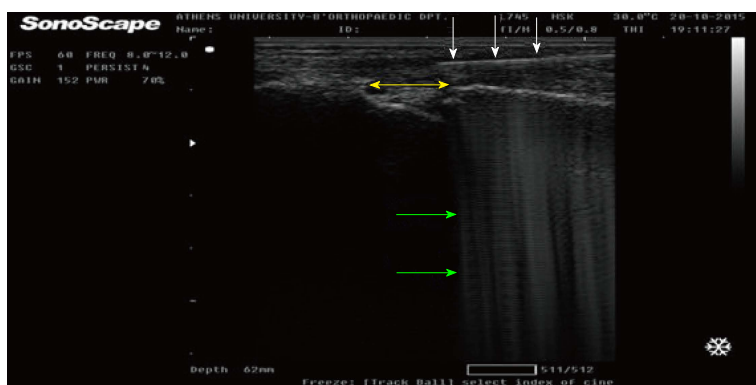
Longitudinal ultrasound-guided release of the A1 pulley. The knife -with its acoustic shadowing (green arrows) - is clearly visible (white arrows). Its tip is advanced over the metacarpal-phalangeal joint (yellow arrow), parallel to the superficial flexor tendon.
